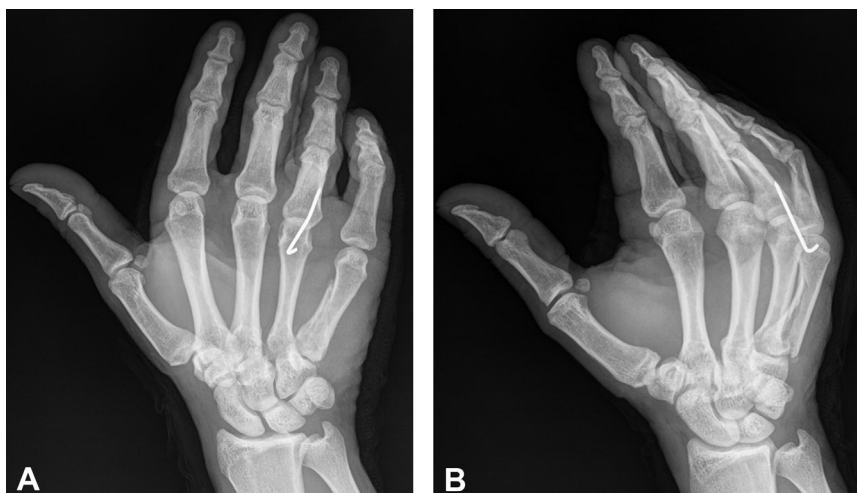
A Anteroposterior x-ray of the patient's left hand at presentation. Notice the dislocation of the fourth MCP, as indicated by the overlapping metacarpal head over the base of the proximal phalanx and by the oblique fracture of the fifth metacarpal. B Oblique x-ray at presentation. Notice the dislocation of the base of the proximal phalanx of the ring finger and the oblique fracture of the fifth metacarpal.
